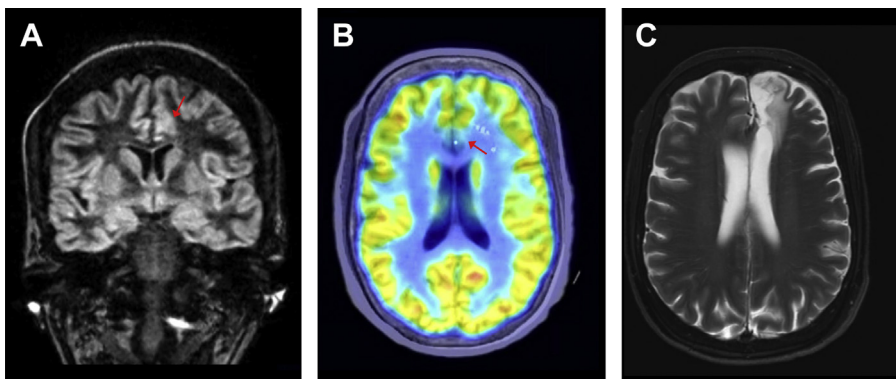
Patient presenting with focal seizures related to FCD, with scalp EEG maximal over the midline frontal area at onset. (A) Double inversion recovery MRI head reveals thickened cortex with blurring of the gray-white matter border over the anterior cingulate (*red arrow*). (B) FDG-PET shows bilateral hypometabolism in the anterior cingulate (*red arrow*), and SEEG monitoring shows seizures arising from the left anterior cingulate. (C) Focal resection of the FCD lesion including the locations of the seizure onset electrodes rendered the patient seizure free as of 25 months follow-up.
